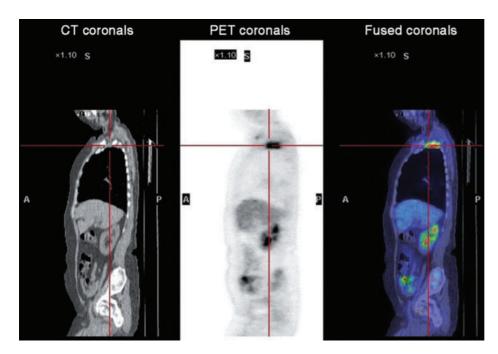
Coronal CT, PET and fused scan images of upper thoracic region in September 2005 (two months following chemo-radio-therapy) demonstrating marked reduction in the uptake by the right apical lung lesion
